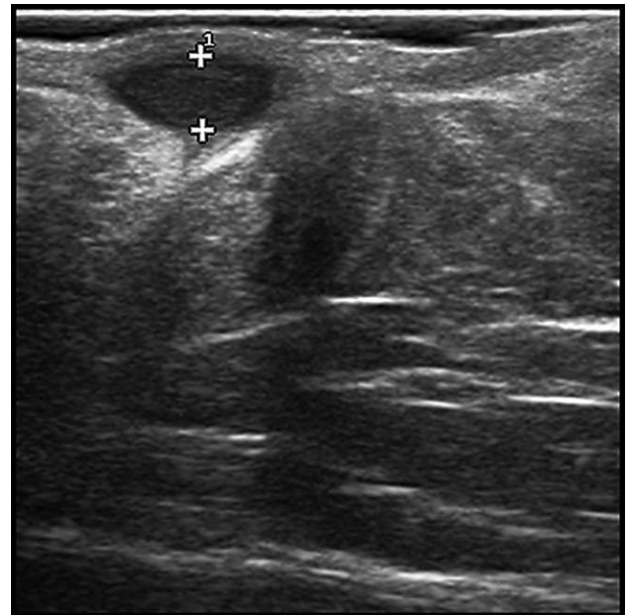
Measurement (4 mm) of the diameter of a clinical axillary inflammatory nodule by grey scale ultrasound. The nodule represents a fluid collection in the dermis and upper subcutaneous tissue.
